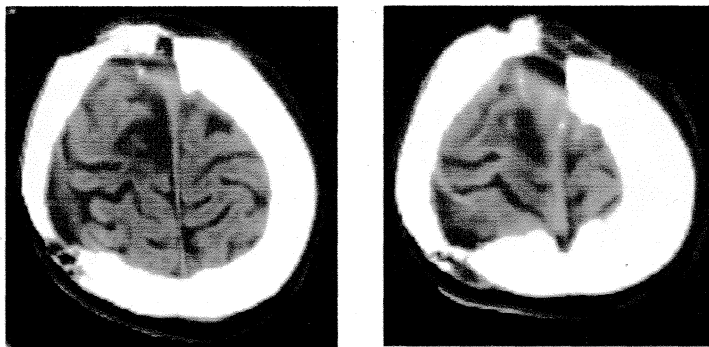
Postoperative CT scan showing extent of excision
